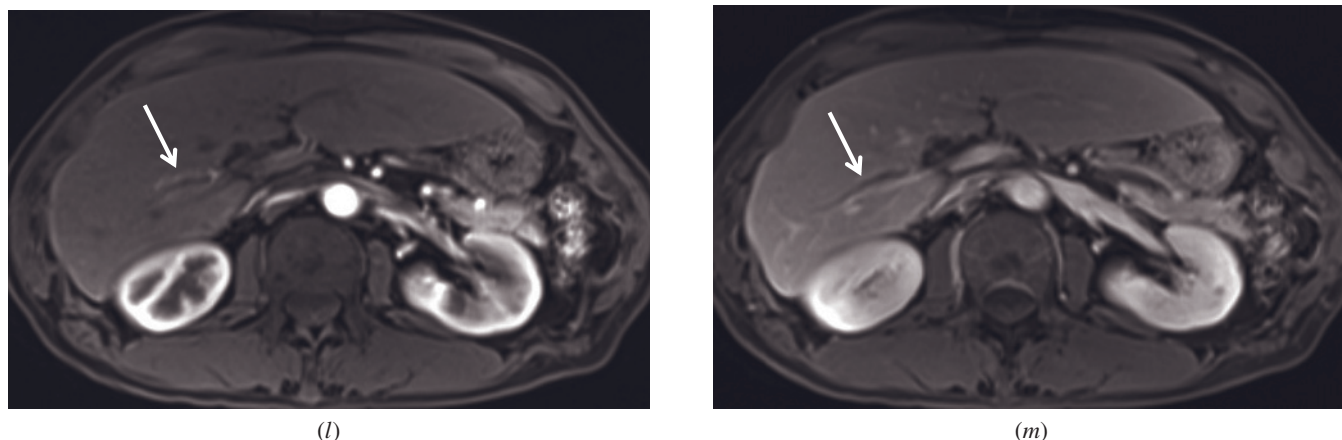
(Continued) transverse T1-weighted postgadolinium fat-suppressed true late hepatic arterial phase (*l*), and hepatic venous phase (*m*) 3D-GE images demonstrate ascending cholangitis and choledocholithiasis in another patient. The common bile duct and intrahepatic bile ducts are dilated because of the stone (arrows, *j*, *k*) in the common bile duct. A dilated duct (arrows, *l*, *m*), which shows increased wall enhancement on postgadolinium images, is shown (*l*, *m*). These findings are suggestive of ascending cholangitis.
